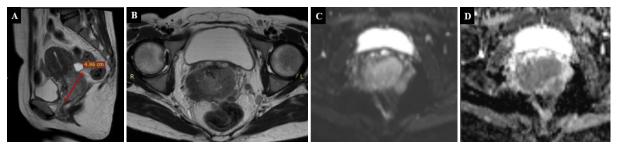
Pelvic MRI Examination of Case 4
